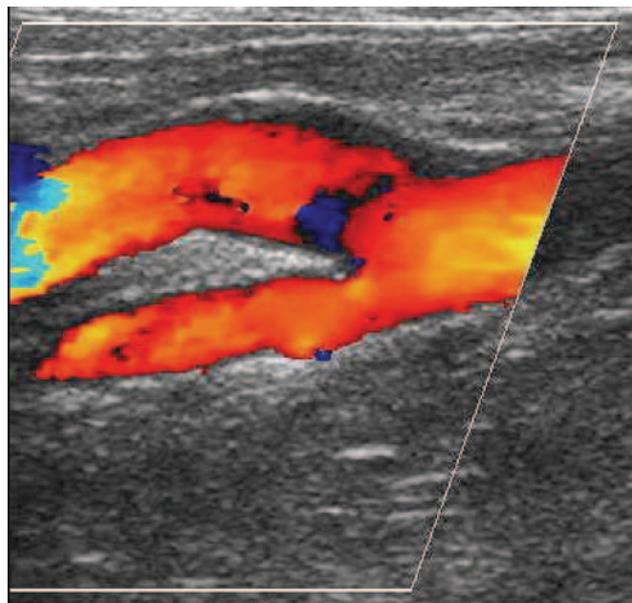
Ultrasound image of a healthy carotid artery and its 2 branches. The red color indicates blood flow through the artery.
